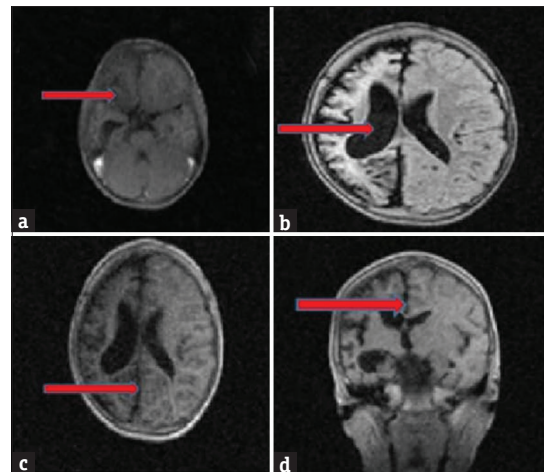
MRI showing right cerebral hemiatrophy and encephalomalacia (a) dilated lateral ventricle, mass effects, cerebral hemiatrophy and hypertrophic calvarium (b and c), and hyperpneumatization of sinuses (d) respectively
